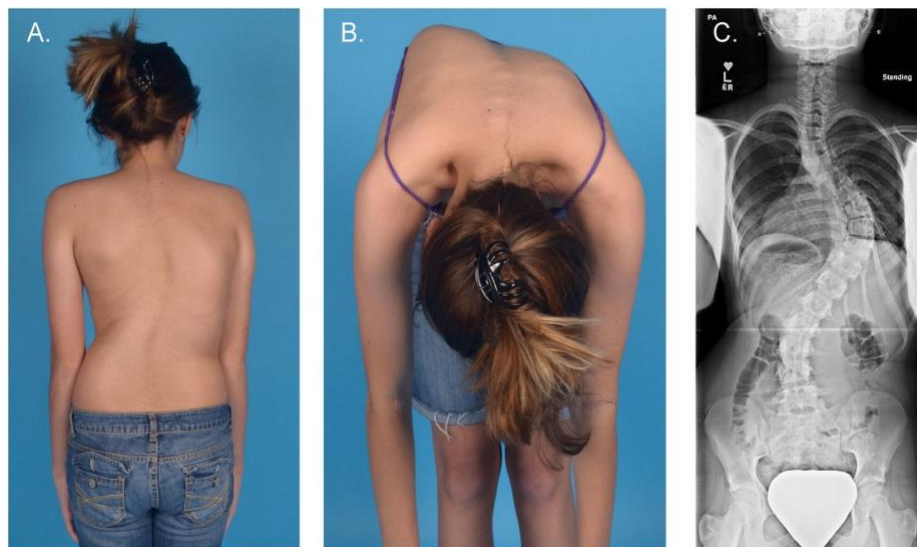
A patient with Idiopathic Scoliosis and the X-ray image of her spine (Paria et al., 2015).
